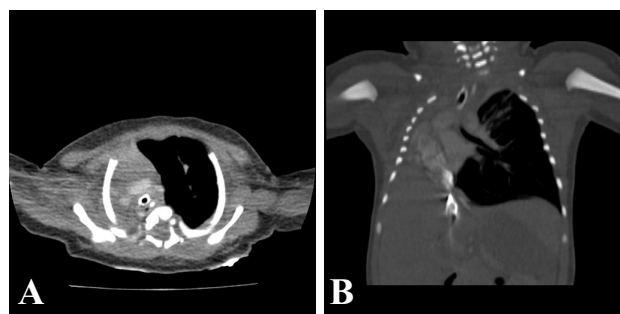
A and B. Chest computed tomography scan showing right pulmonary hypoplasia with cervical spine anomalies.
